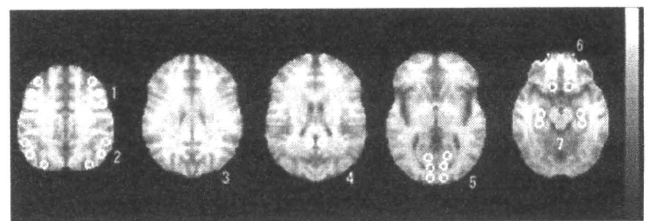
Regions of interest (ROI) on the magnetic resonance imaging (MRI) template images. The ROI shown on the horizontal MRI template images of Neurological Statistical Image Analysis Software (University of Michigan, Ann Arbor, MI, USA). The anatomical locations of ROI are as follows: 1 and 6, frontal lobe; 2, parietal lobe; 3 and 4, posterior cingulate cortex; 5, occipital lobe; 7, medial temporal lobe.
